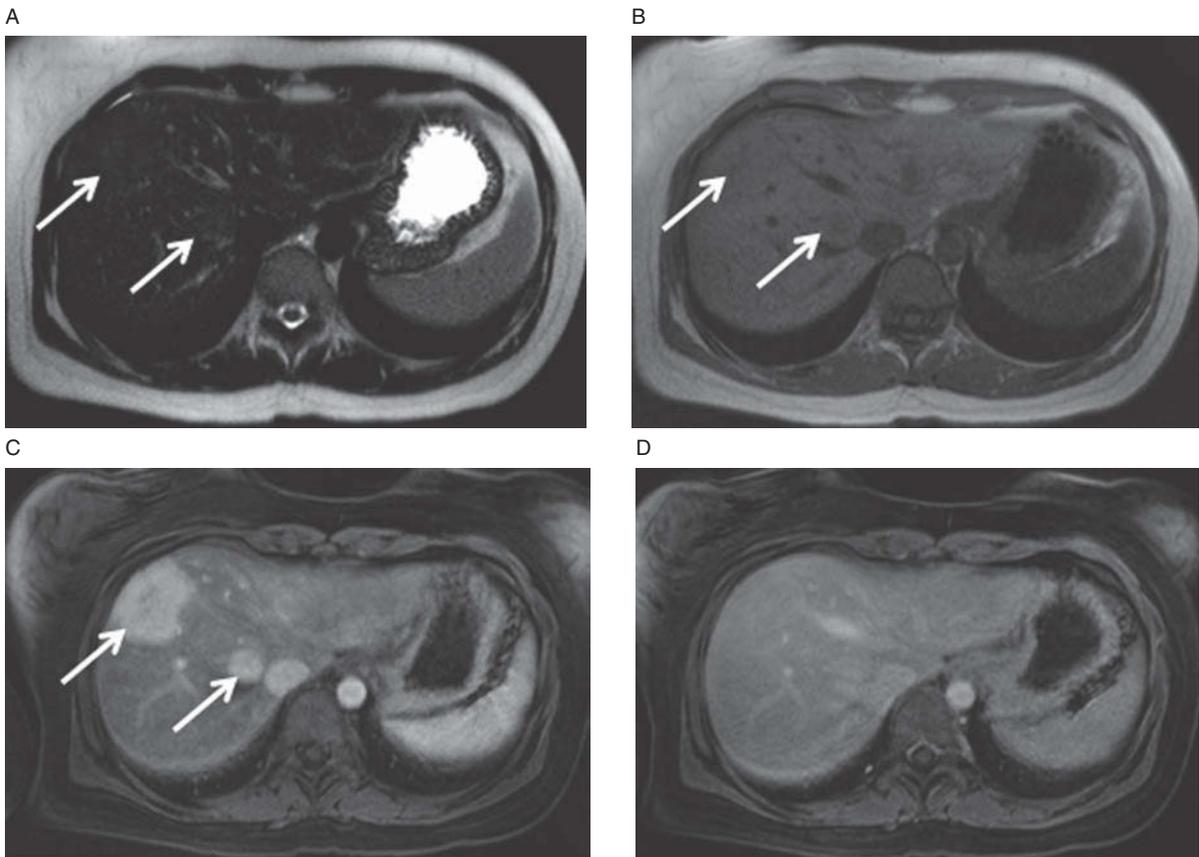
Multiple focal nodular hyperplasias (FNHs). T2-weighted image (A) and T1-weighted image (B) demonstrate two, barely perceptible lesions within the liver (arrows). These lesions enhance avidly on arterial-phase T1-weighted, fat-saturated image (arrows, C) and are imperceptible on delayed image (D).
